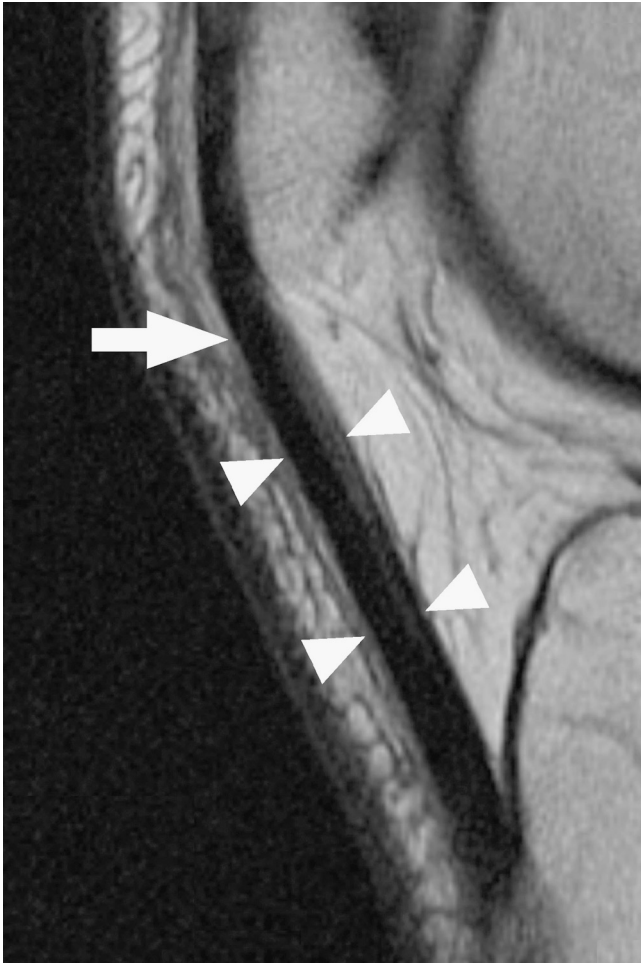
Symptomatic 24-year-old male subject, imaged using proton-density weighted magnetic resonance imaging (4050/38). Note the absence of altered signal intensity within the proximal patellar tendon (arrow) and relatively uniform thickness of the tendon in the anteroposterior direction along its length (arrowheads). This contrasts with this participant's gray-scale ultrasonography and color Doppler ultrasonography images (Figures 2B and 2C), which confirmed the clinical diagnosis.
